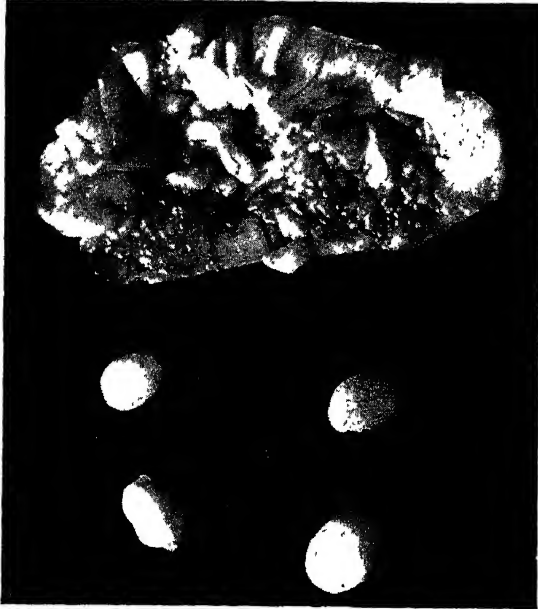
An area of disintegrating cartilage excised from the articular surface of the patella, and four smooth rounded cartilaginous loose bodies which had become detached from the degenerated area and were removed from the knee joint at the time of operation. They contained no calcium and therefore were not demonstrable by roentgenogram. (Case 1.) (Cave, E. F., Rowe, C. R. and Yee, L. B. K.: *Surg., Gynec. & Obst.* 81: 446 (Oct.) 1945.)
